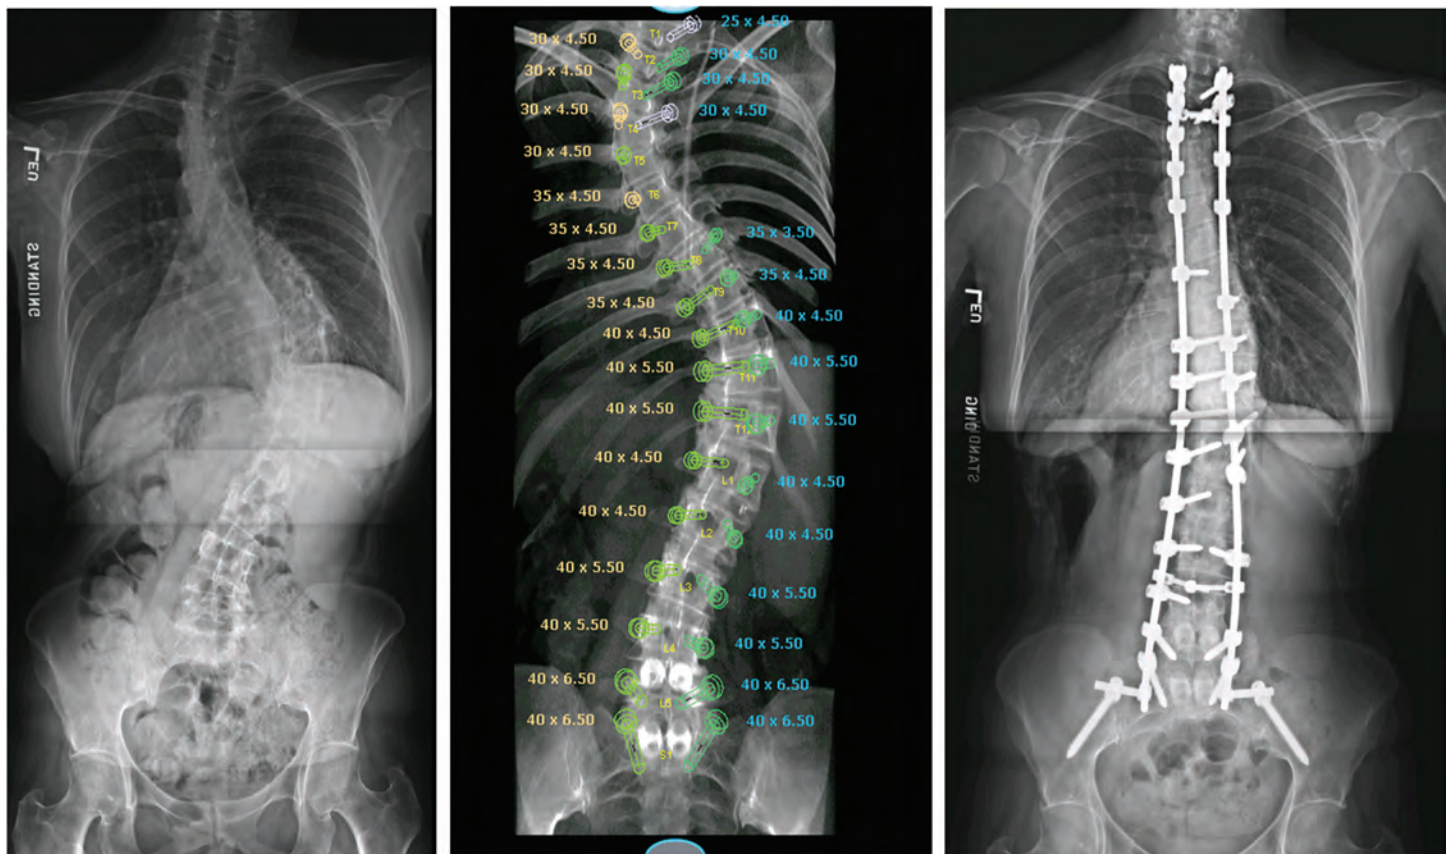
Left: x-ray of patient with large thoracic and lumbar scoliosis which is affecting heart and lung function. Center: pre-operative blueprint, showing the location where screws will be placed during scoliosis correction surgery. Right: final location of the implants after surgical correction.
